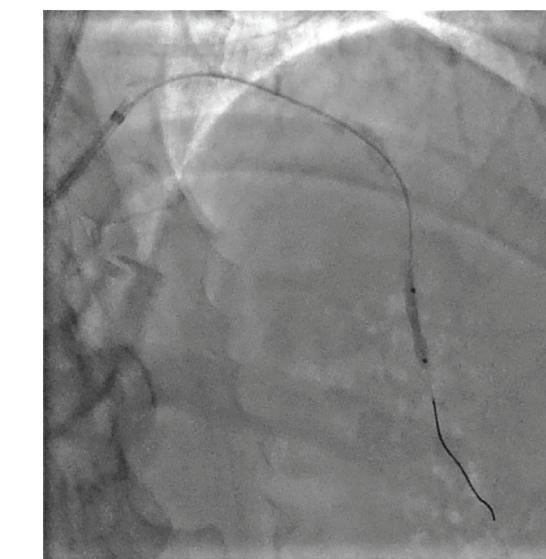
A 75-year-old female with non-ST elevation myocardial infarction (NSTEMI) with very heavily calcified diffuse tandem left anterior descending (LAD) coronary artery lesions. Intravascular ultrasound (IVUS) confirmed stenosis severity, showing a minimal lumen area (MLA) of 2.0 mm^2 with a dense arc of calcification (>180 degrees), but would not fully cross the proximal disease.
